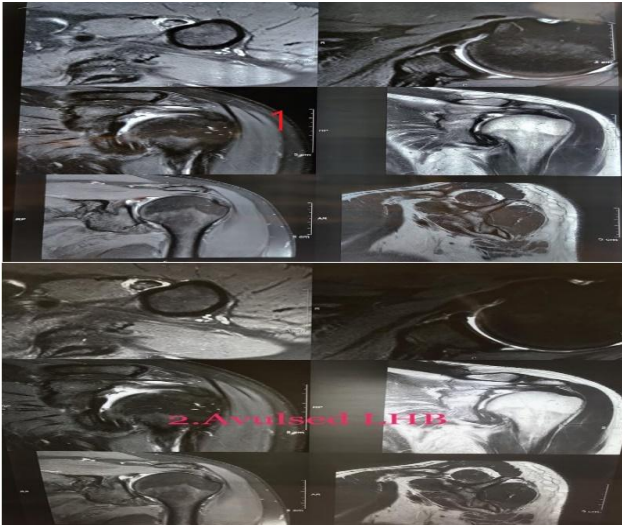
MRI showing avulsed long head of biceps
